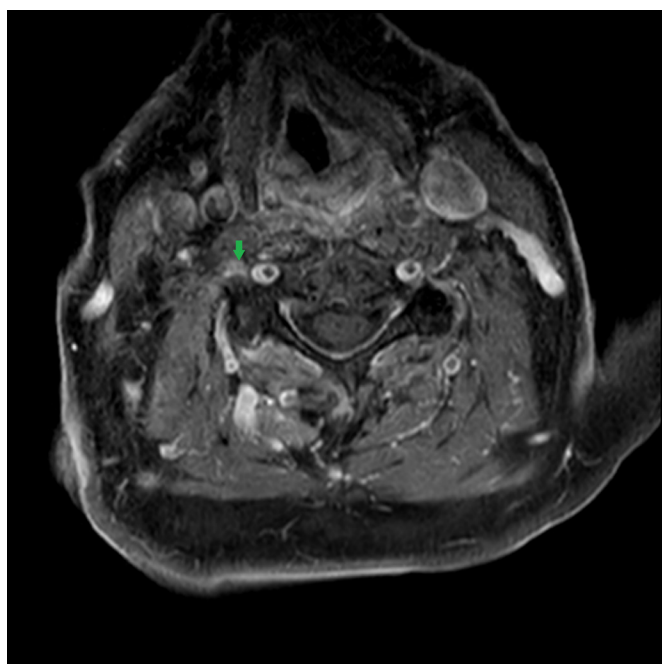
MRI image of gadolinium contrast enhancement on right C5 nerve root (green arrow).
